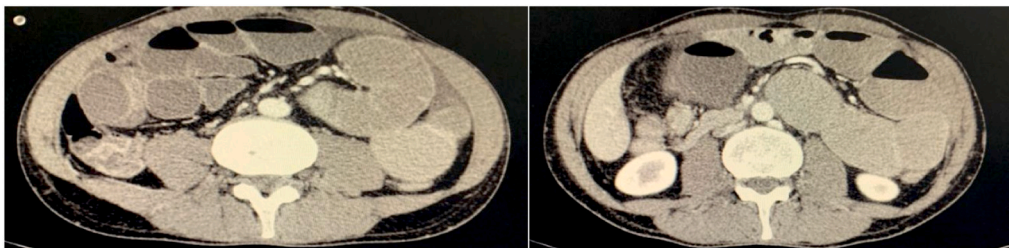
CT scan revealing distended small bowel loops.
